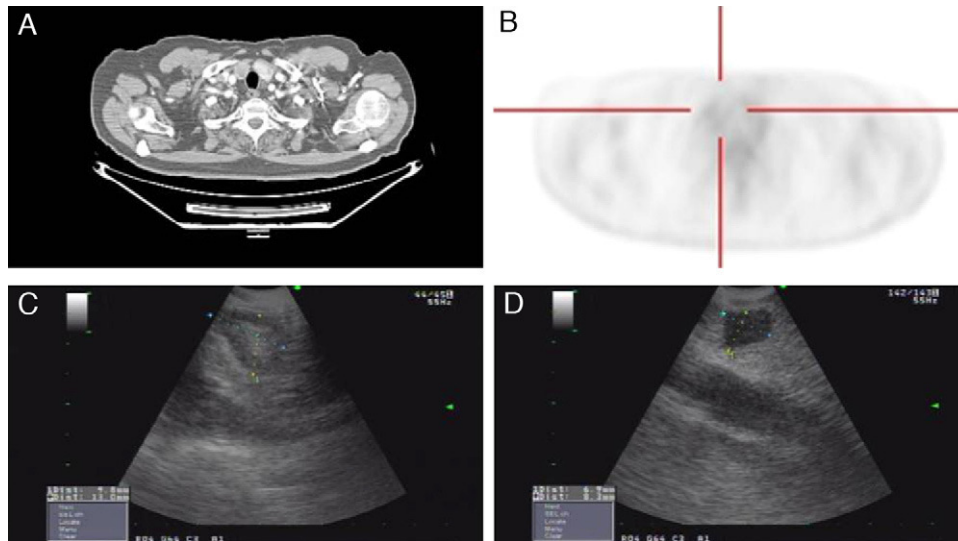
(A) Axial chest CT slice in the mediastinal window showing an upper right paratracheal nodule. (B) The cross-sectional PET-CT slice shows evidence of a right upper paratracheal lesion that is discretely hypermetabolic. (C) Ultrasound image of the lower right paratracheal lymphadenopathy, measuring 13 mm × 10 mm, with a fatty center. (D) Subglottic hypoechoic nodular image, measuring 8 mm × 7 mm, corresponding with a thyroid cyst.
